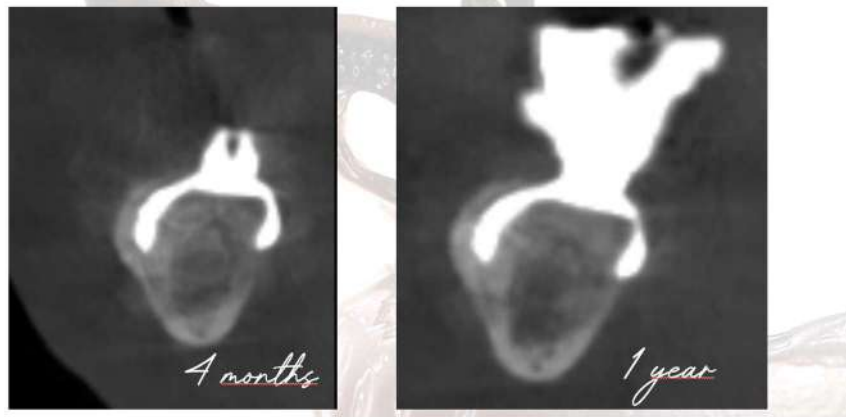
Radiological assessment of intraosseous integration over time. Cross-sectional CBCT images obtained at 4 months and 1 year following implant placement. Progressive radiographic densification can be observed above the implant framework, suggesting ongoing bone formation and maturation within the regenerated compartment. These findings are consistent with the concept of an intraosseous-subperiosteal implant, where the external surface of the framework becomes progressively incorporated into newly formed bone over time.
